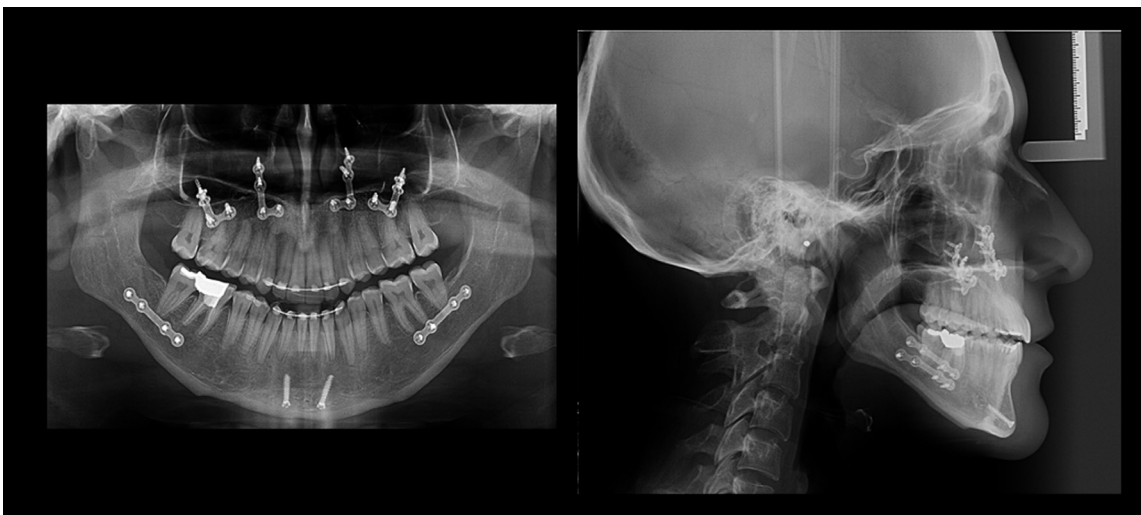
Post-treatment panoramic and lateral cephalometric radiographs.
